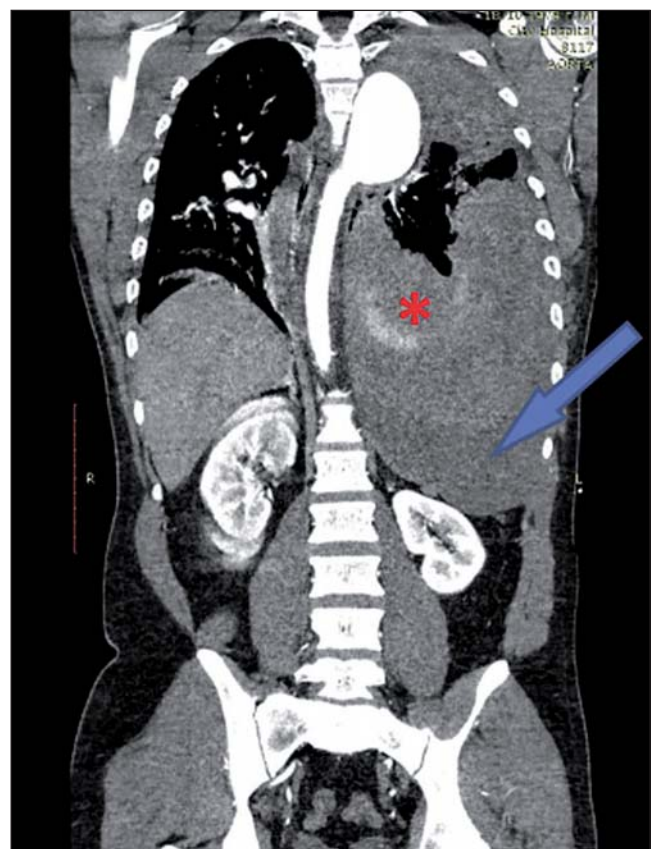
Initial CT aortography with active bleeding persisting.
